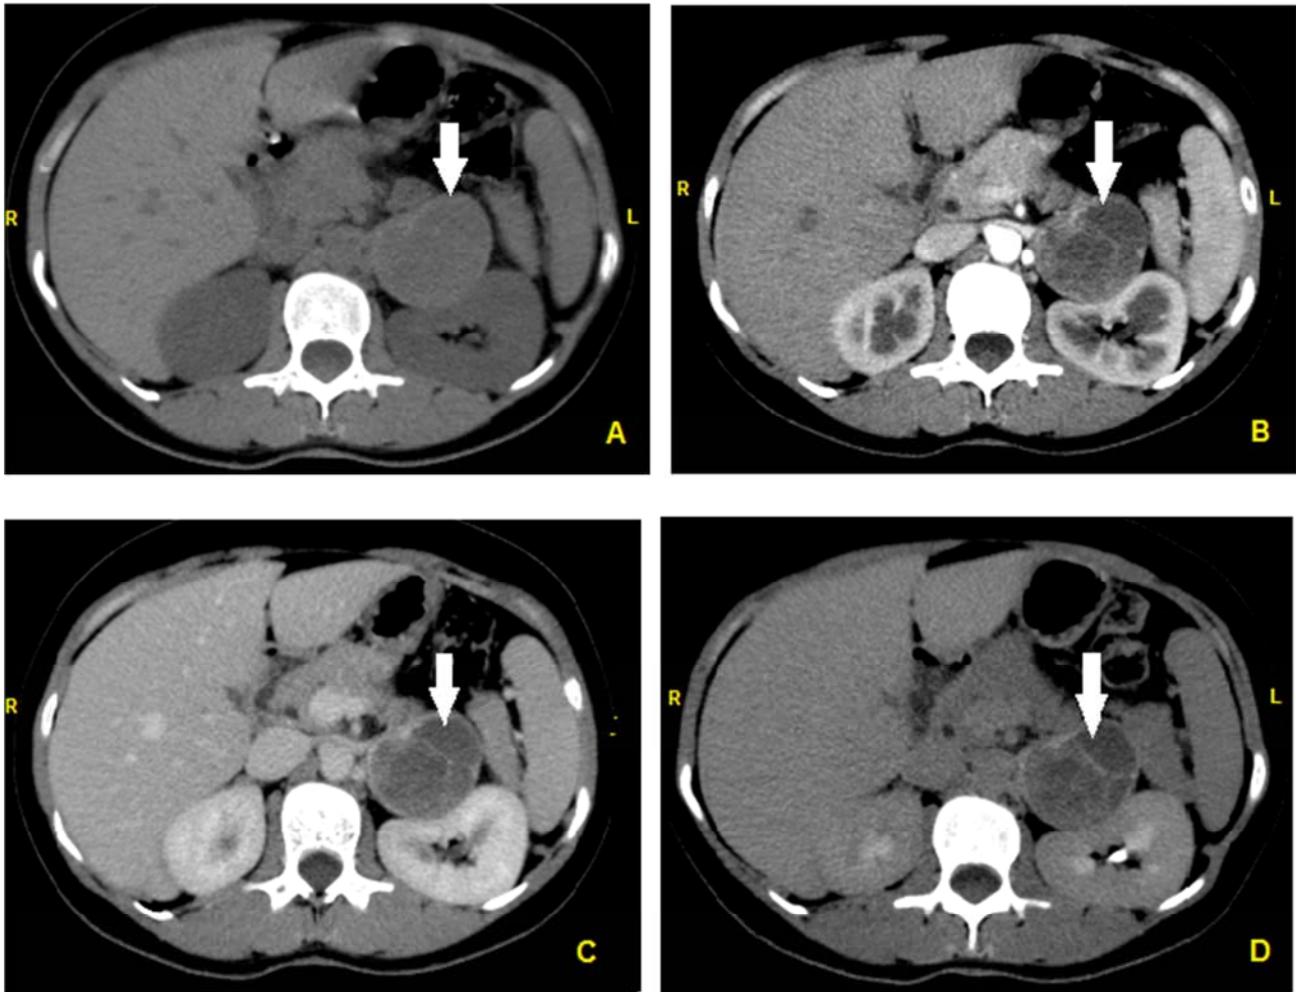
Abdominal-pelvic computed tomography showing a heterogeneous mass at the expense of the left adrenal gland including the calculation of the relative wash-out (15%) in favor of a pheochromocytoma (In the axial plane, A: non-enhanced CT; B: contrast-enhanced CT arterial phase; C: contrast-enhanced CT venous phase and D: contrast-enhanced CT delayed phase 10 min after).
